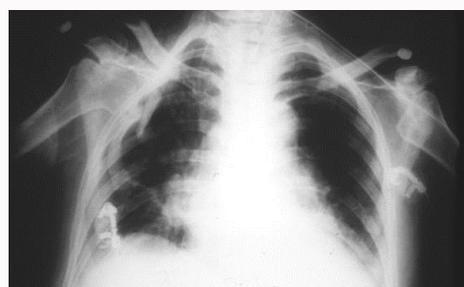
Chest X-ray demonstrated a deformation of the humeral heads suggesting osteonecrosis.
